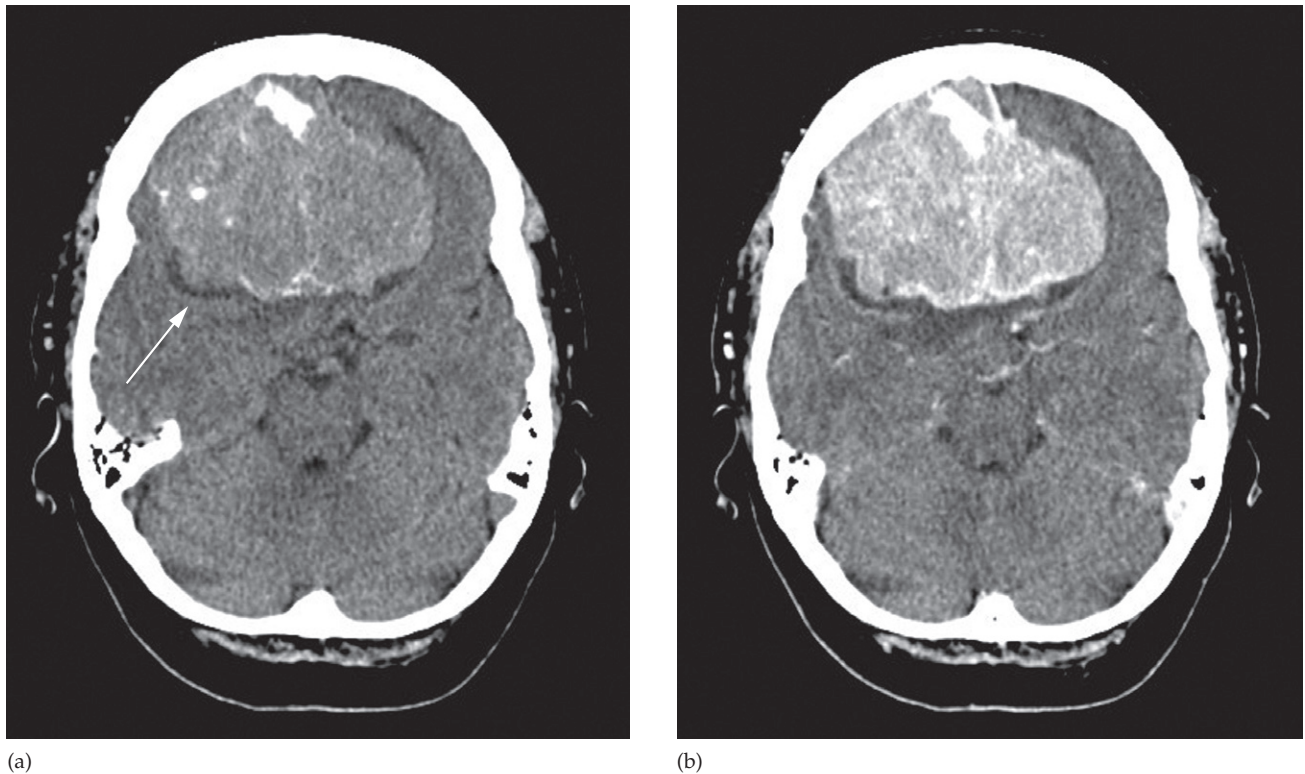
Meningioma. (a) CT scan pre contrast showing a partially calcified mass in the anterior cranial fossa. There is low density CSF between the mass and the displaced grey matter cortex (arrow) indicating the tumour is extra-axial in location. (b) CT post contrast showing prominent enhancement of the mass typical of a meningioma. Also note the normally enhancing vessels which are also extra-axial and between the mass and brain.
